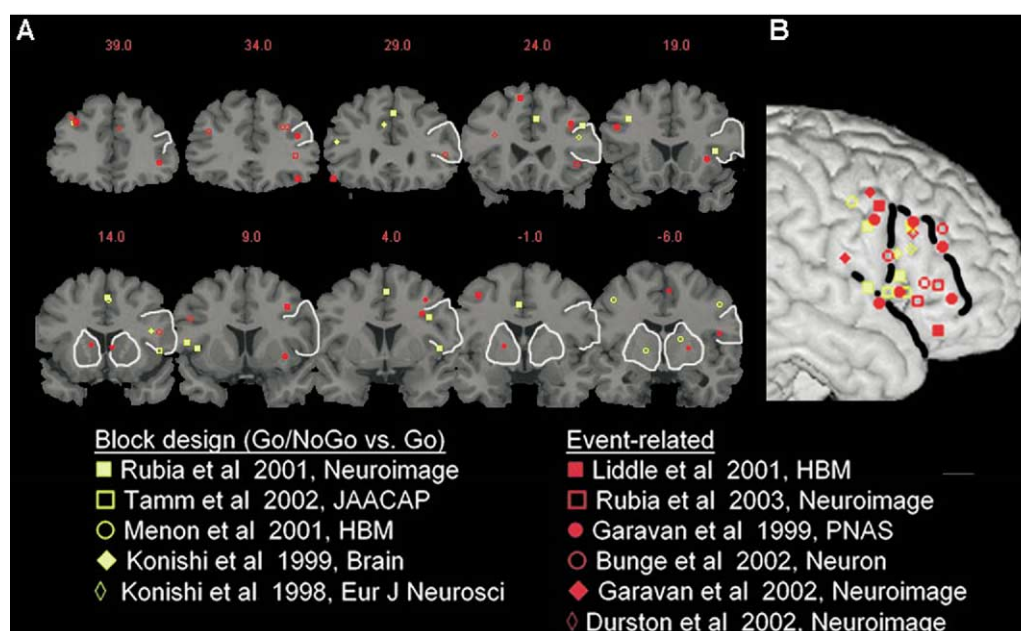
Meta-analysis of response inhibition functional MRI studies in healthy volunteers (please see online article for color). All frontal and basal ganglia activation foci in the range $-7 < y < 41$ (Talarach coordinates) reported in 11 studies are plotted on (A) coronal slices and (B) lateral/sagittal view of a standard structural template. Yellow activations reflect blocked Go versus Go/NoGo studies (Konishi et al 1998, 1999; Menon et al 2001; Rubia et al 2001; Tamm et al 2002); red activations reflect event-related studies contrasting Go with NoGo trials (Bunge et al 2002; Durston et al 2002; Garavan et al 1999, 2002; Liddle et al 2001) or using the Stop-signal paradigm (Rubia et al 2001, 2003). Although activations fall within dorsolateral, ventrolateral, medial, and premotor (precentral gyrus), it is evident that: 1) more frontal activations fall within the right hemisphere, 2) most frequently the activations within the right frontal region fall within the inferior frontal (ventrolateral) region of the prefrontal cortex, and 3) only a few studies report basal ganglia activation. On the sagittal view, the sulcal boundaries of the inferior frontal gyrus are shown.
